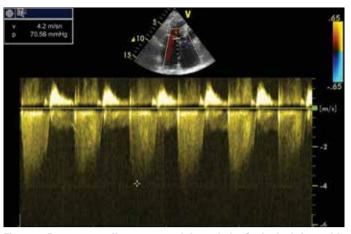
Pressure gradient measured through the Gerbode defect with CW Doppler echocardiography in apical four-chamber view
